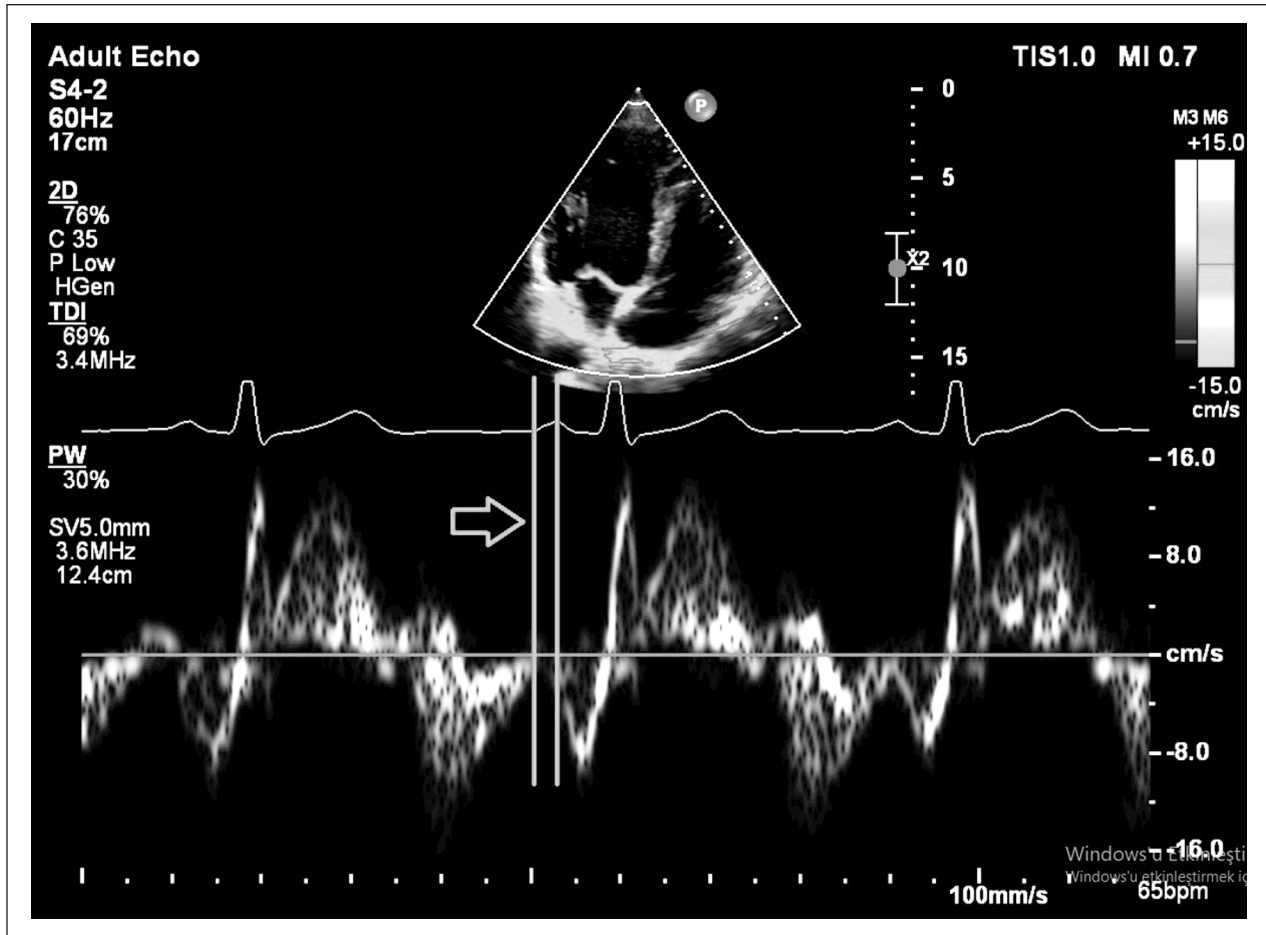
Measurement of the PA interval (atrial electromechanical coupling time) using tissue Doppler imaging.
